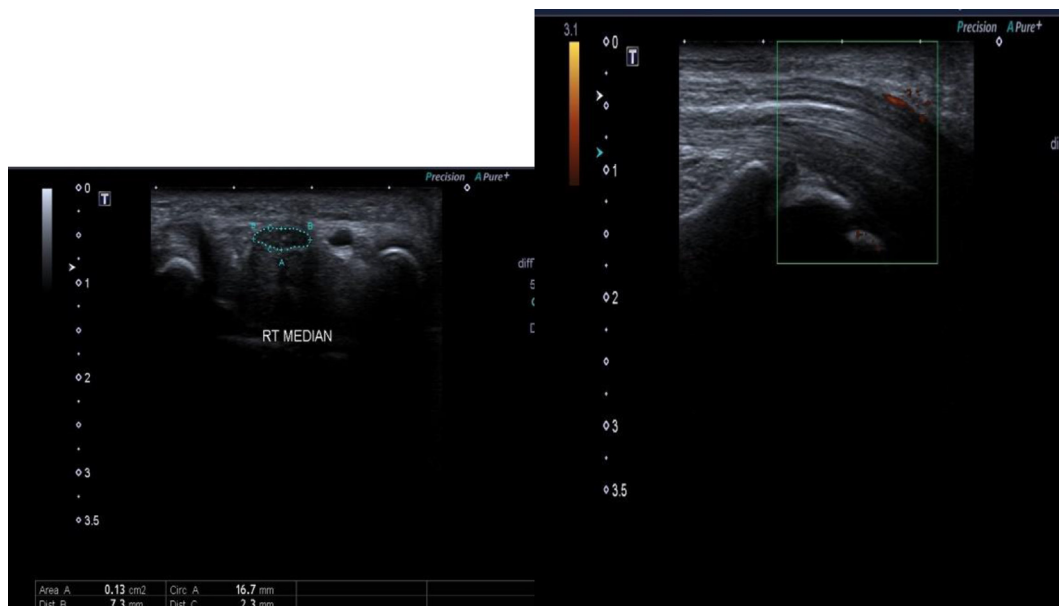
CSA, flattening ratio, Doppler signal of the median nerve at the inlet of the carpal tunnel. CSA, cross-sectional area.
